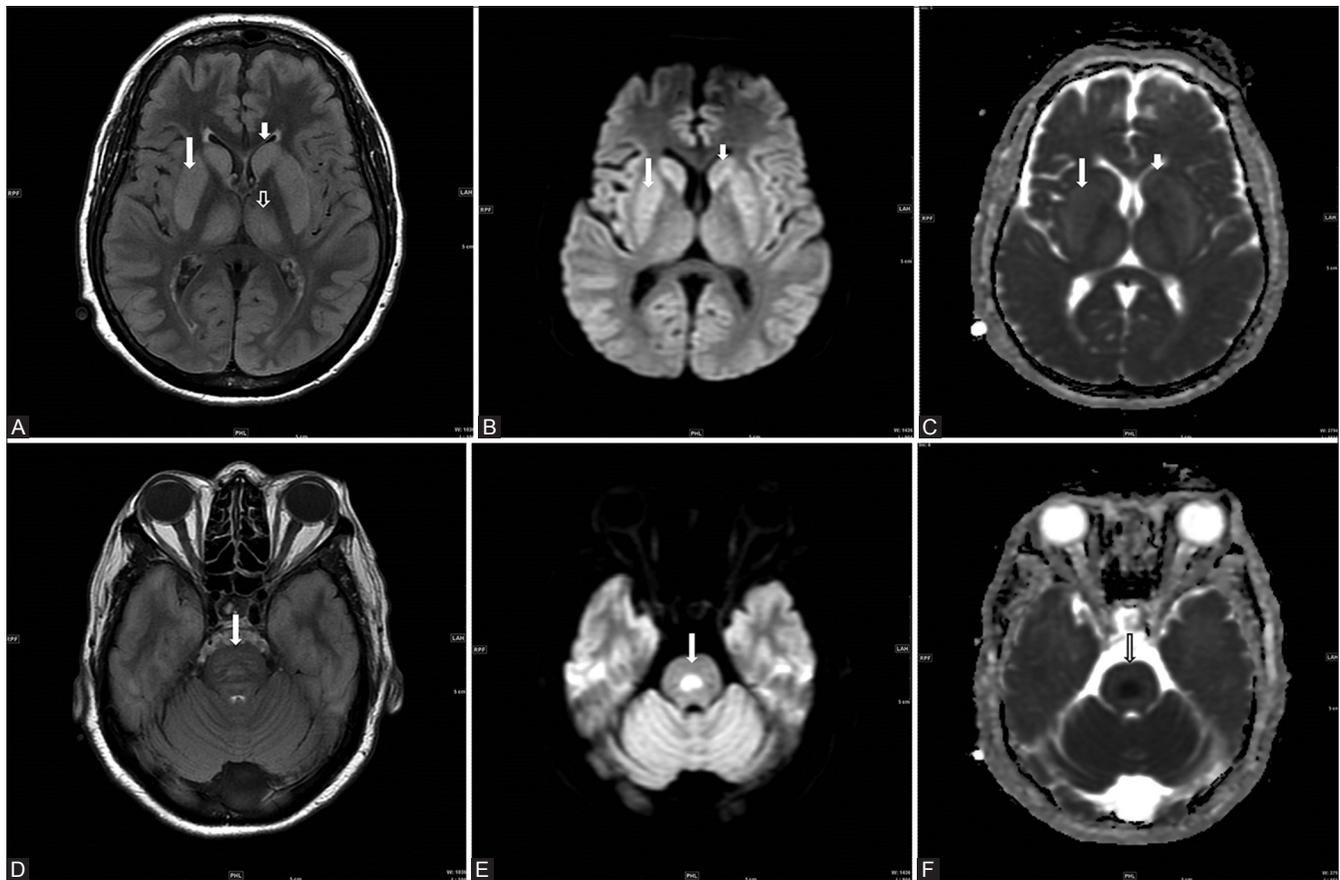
Case 1 (2nd MRI - 7days after correction of hyponatremia) (A) Axial FLAIR section at the level of basal ganglia shows hyperintense signal in both caudate heads and putamina as well as in thalami (B) Axial DWI section at the level of basal ganglia shows hyperintense signal in basal ganglia i.e. both caudate heads and putamina as well as in thalami (C) Axial ADC map at the level of basal ganglia shows high ADC values suggestive of decreased diffusion restriction and T2 shine through effect (D) Axial FLAIR section at the level of pons shows hyperintense signal in the central pons. (E) Axial DWI section at the level of pons shows diffusion restriction within central pons (F) Axial ADC map at the level of pons shows low ADC values in central pons suggestive of strong diffusion restriction (central pontine myelinolysis)
